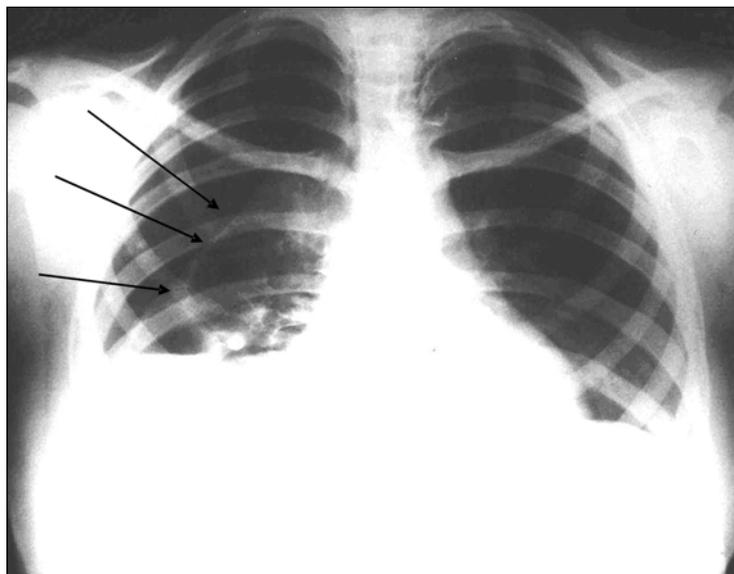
Chest radiograph performed 24 hours later in upright position, after barium sulphate ingestion. Heart limit is precisely outlined with lung structures inside. On the right side (above the diaphragm), horizontal barium level with radiolucent areas above. Lateral, the radiolucent areas are limited by a clear contour, like a wall containing all hydroaerial images.
